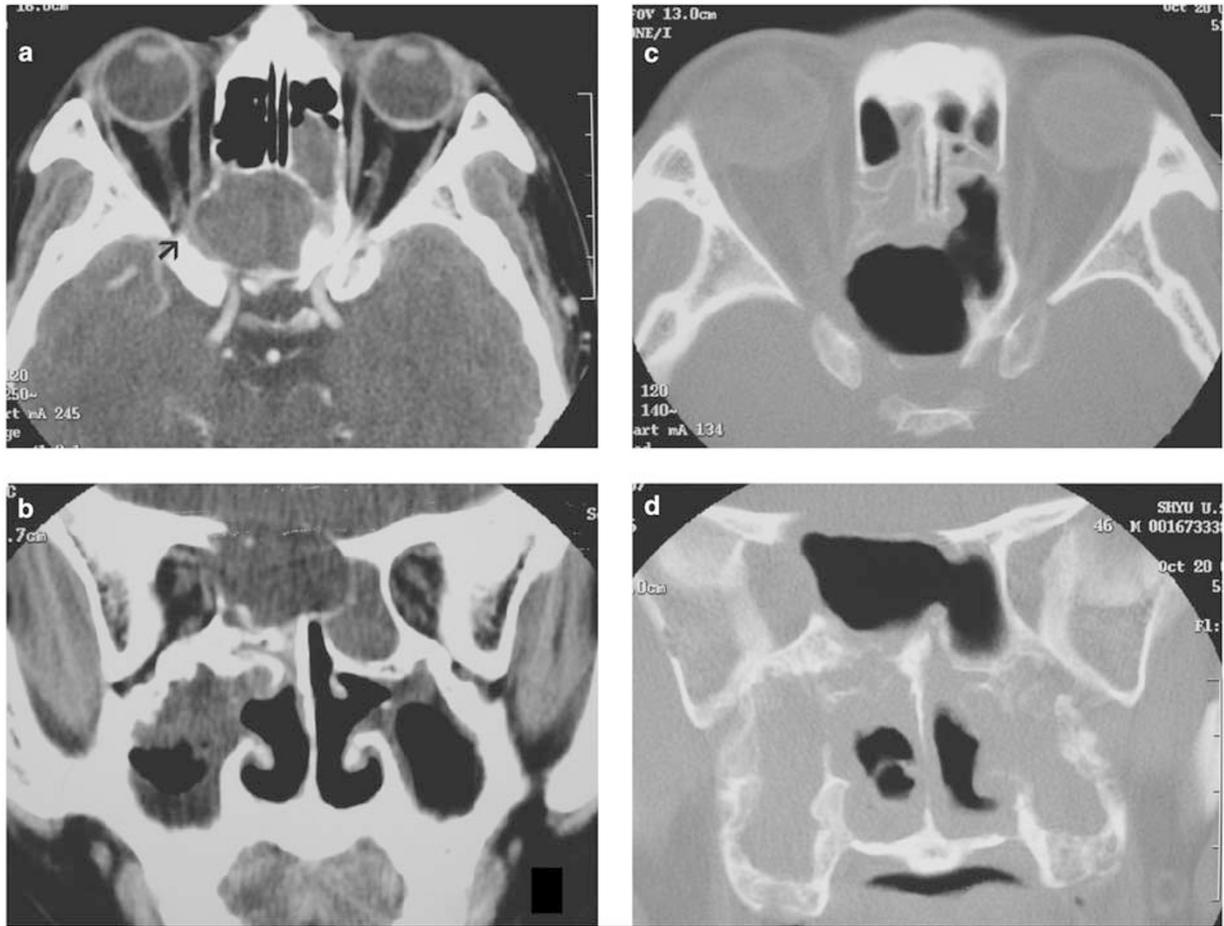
Preoperatively, axial (a) and coronal (b) contrast enhanced CT scan showed an expanded lesion in the right sphenoid sinus with thinning and erosion of the sinus wall into the right orbit. Optic nerve compression was noted (a, arrowhead). Postoperatively, axial (c) and coronal (d) CT scan without contrast showed a decompressed sphenoid air space with mucosal thickening, which was previously filled with mucocoele.
